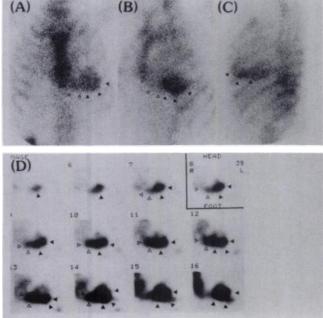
Technetium-99m-pyrophosphate scintigrams from anterior (A), left anterior oblique (B), and left lateral (C) views, and coronal tomograms (D) demonstrate increased activity in the inferoapical region of the left ventricle (\triangle), inferior septum, and right ventricle (\triangle).
